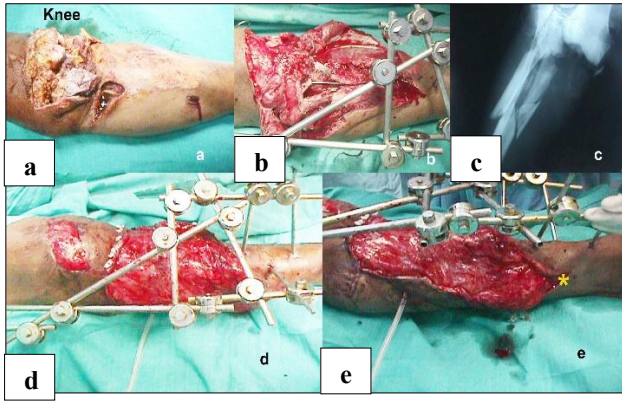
(a-c): Intraoperative images and X-ray of acute wound with segmental fracture upper third leg, and (d and e) coverage with latissimus dorsi muscle flap (*refers to use of anterior tibial vessels distal to the defect at the junction of middle and lower third leg).
